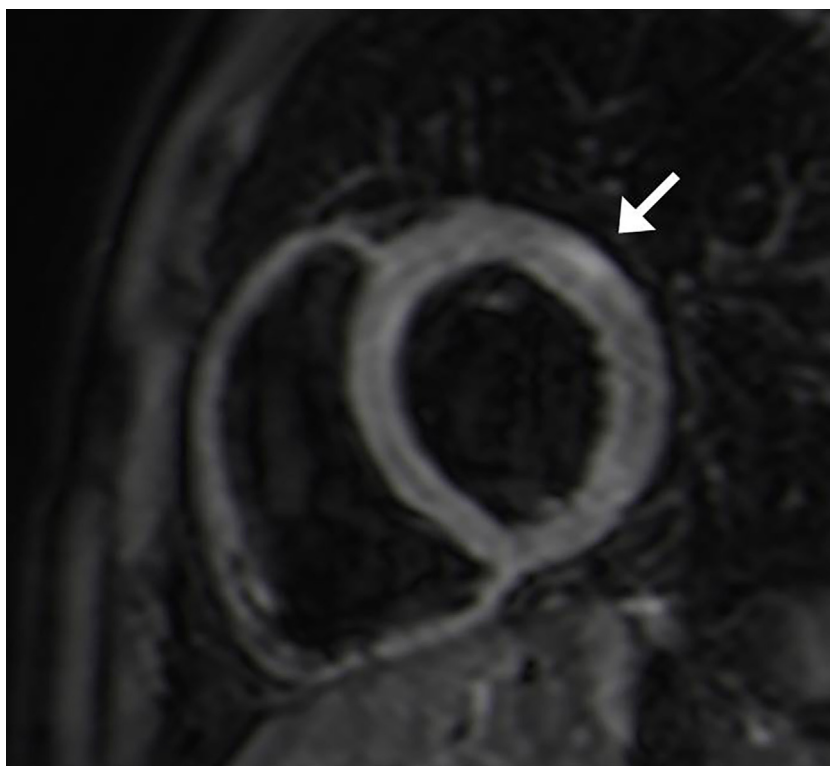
The contrast-enhanced cardiac MRI reveals a marked subepicardial hyperintensity in T2 weighted imaging compatible with a myocardial edema.
